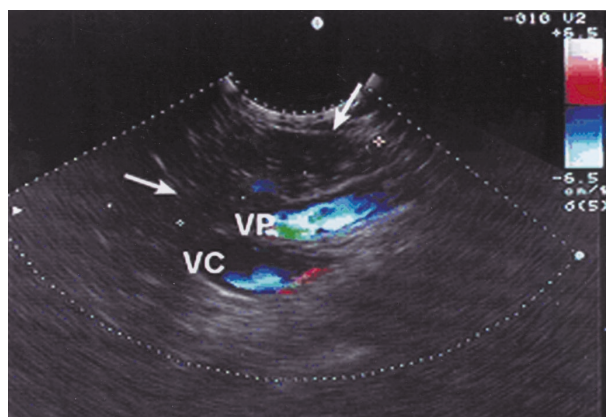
Pancreatic cancer – EUS + Doppler technique – portal vein infiltration
